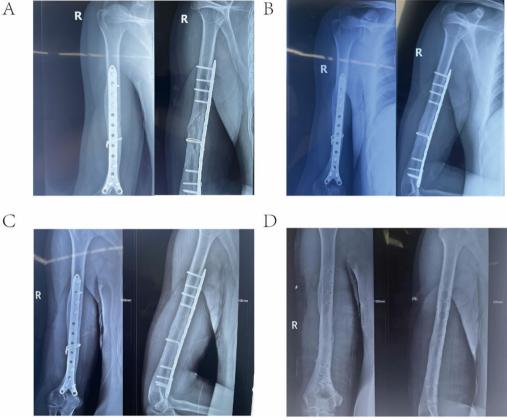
Postoperative X-ray follow-up results of the patient. A-C X-ray pictures of the patient at 3 months, 6 months, and 12 months after operation. D X-ray pictures of the patient after removal of implants such as plates and screws at 14 months after operation
